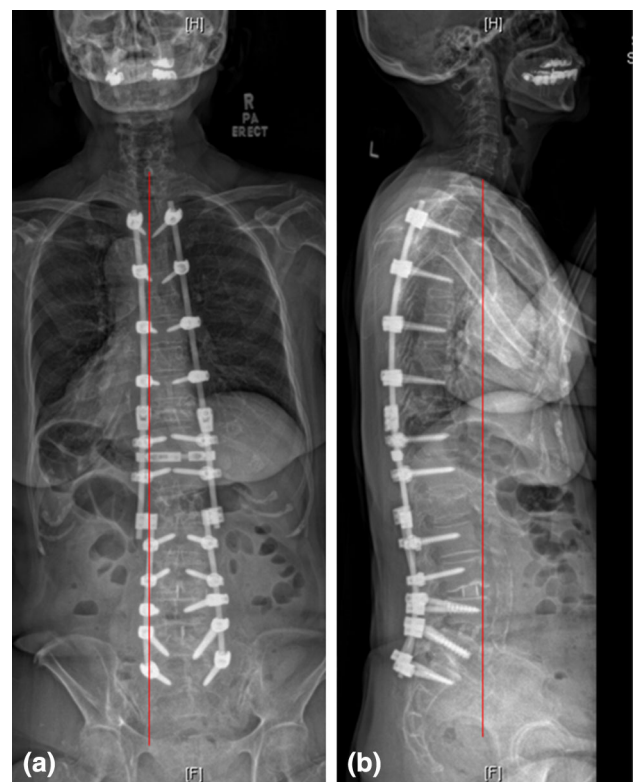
Post-operative erect whole spine radiographs using EOS technology. Post-operative EOS X-ray showed good sagittal balance with an SVA of +3.5 cm, a PI of 70°, an LL of 37°, and a PT of 48°
